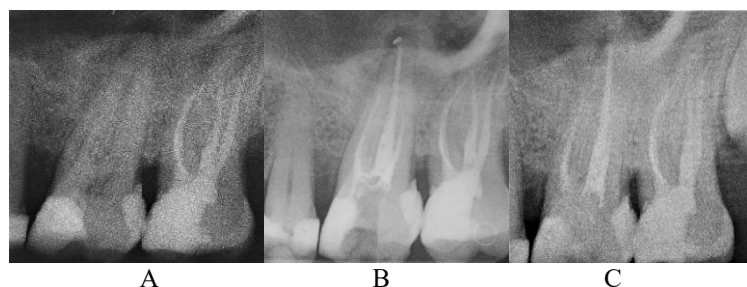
Case 2 (tooth 26): A. Initial radiographic finding; B. Root canal filling; C. The case in 1 year follow-up.
